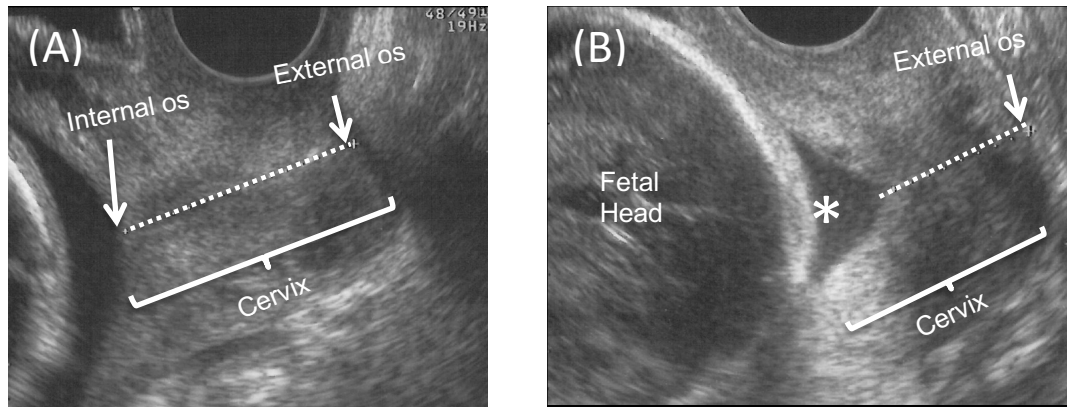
Transvaginal ultrasound scan images displaying changes in the appearance of the cervix in the mid-trimester of pregnancy.
